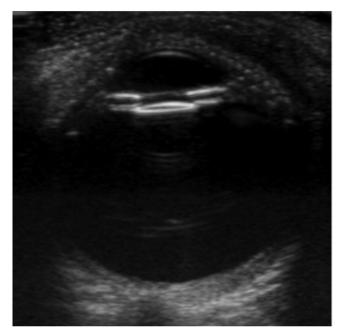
In-flight (L+90) ultrasound image showing a stable, well positioned IOL
